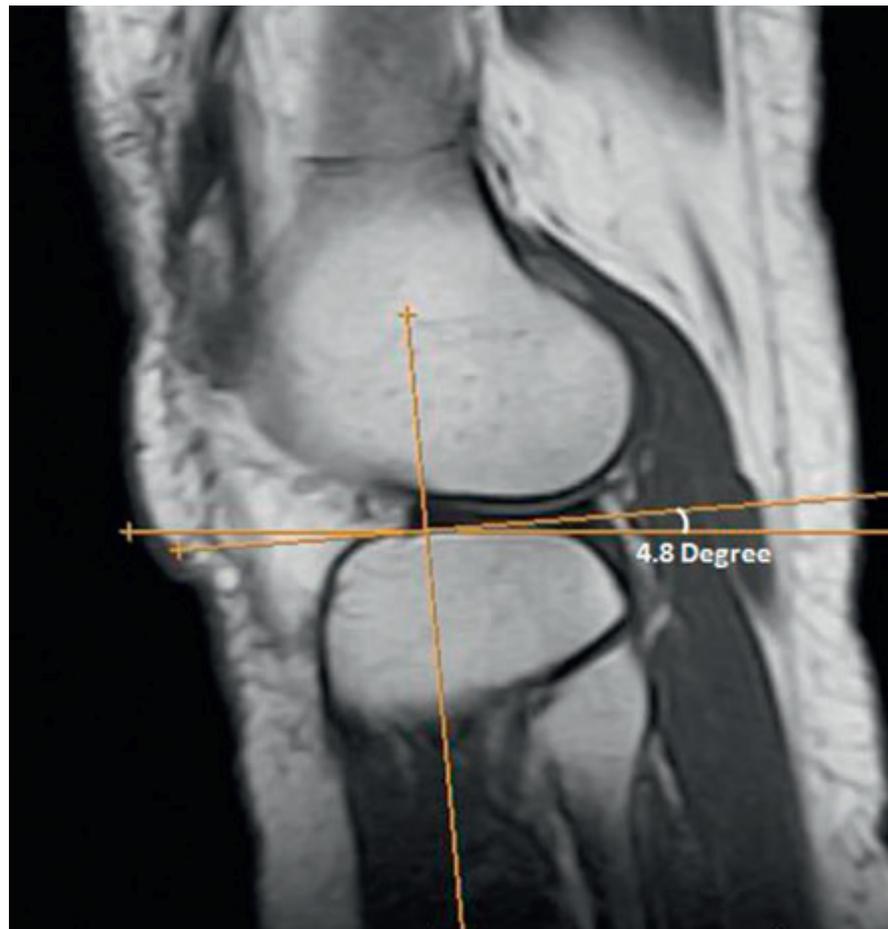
Sagittal section of intermediate weighted image of MRI Method of measuring posterior tibial slope of lateral condyle.
